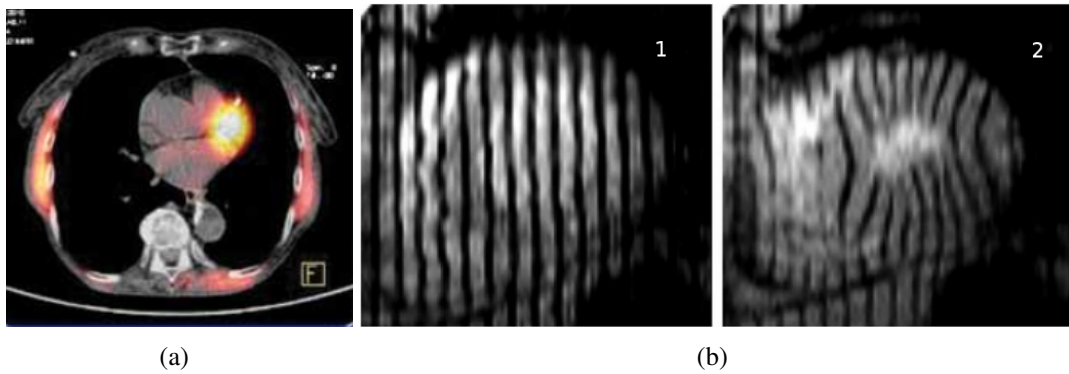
(a) Short-axis view of a combined CT/PET scan of the human heart [82]. CT (in grey) provides the anatomical information, while PET (in colour) represents myocardial viability. Reproduced with permission from Via Medica. (b) Short-axis view of a Tagged-MRI [9] scan at (1) end-diastole and (2) end-systole. Reproduced with permission from Elsevier.
